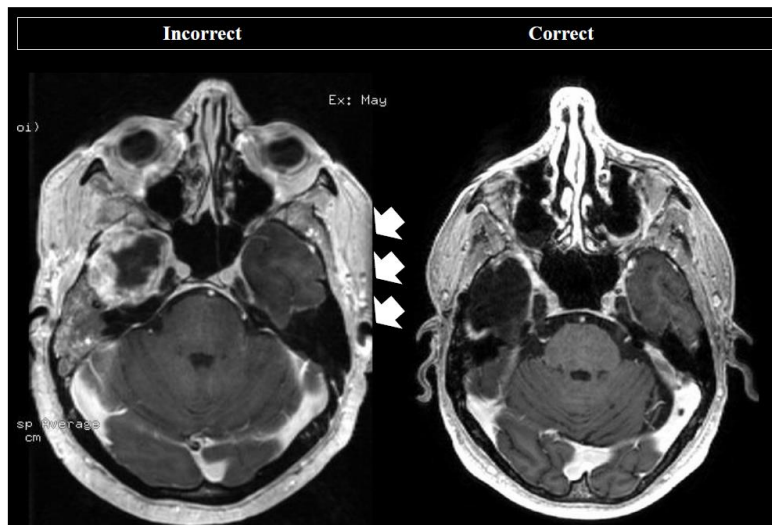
MRI image samples demonstrating field of view of the images must include the surface of the scalp. Incorrect image on the left does not include full scalp surface where indicated by arrows. The correct image at the right does include the surface of the scalp around the entire head.
